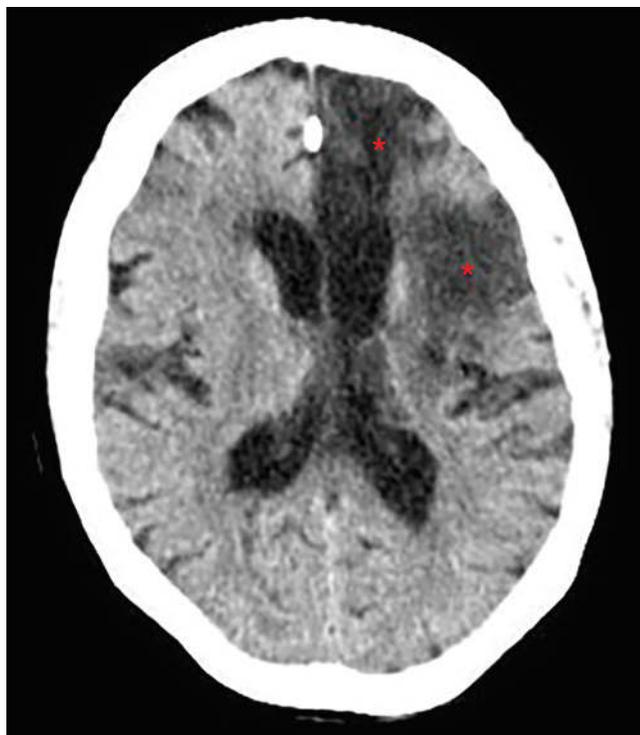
Chronic infarction. Noncontrast CT shows fluid-density encephalomalacia and volume loss in the left anterior and middle cerebral artery territories (*asterisks*) in this patient with chronic left hemisphere infarctions.
